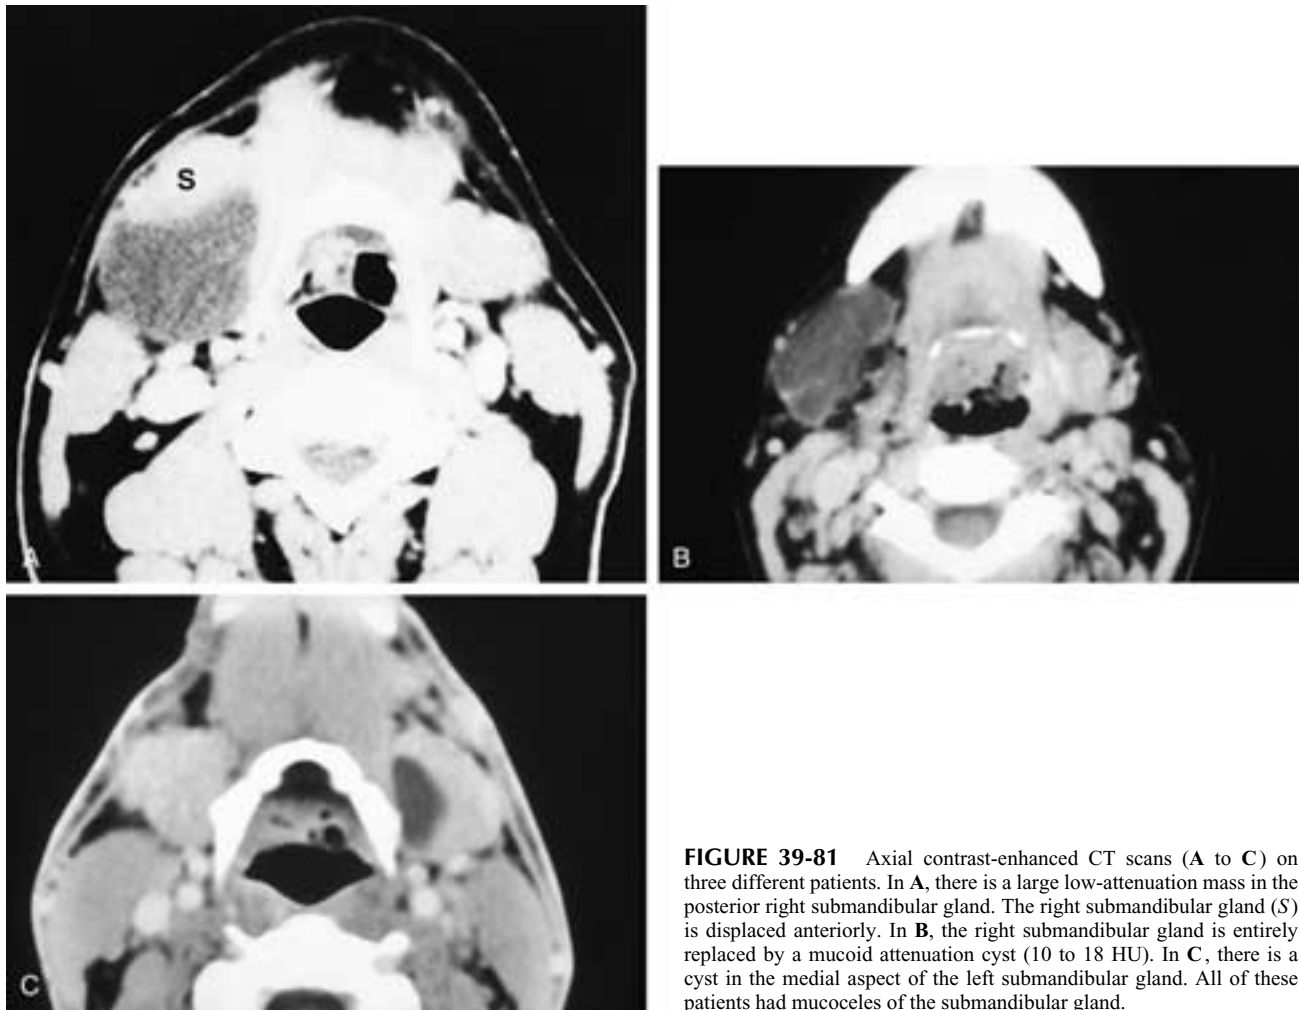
Axial contrast-enhanced CT scans (A to C) on three different patients. In A, there is a large low-attenuation mass in the posterior right submandibular gland. The right submandibular gland (S) is displaced anteriorly. In B, the right submandibular gland is entirely replaced by a mucoid attenuation cyst (10 to 18 HU). In C, there is a cyst in the medial aspect of the left submandibular gland. All of these patients had mucocoeles of the submandibular gland.
